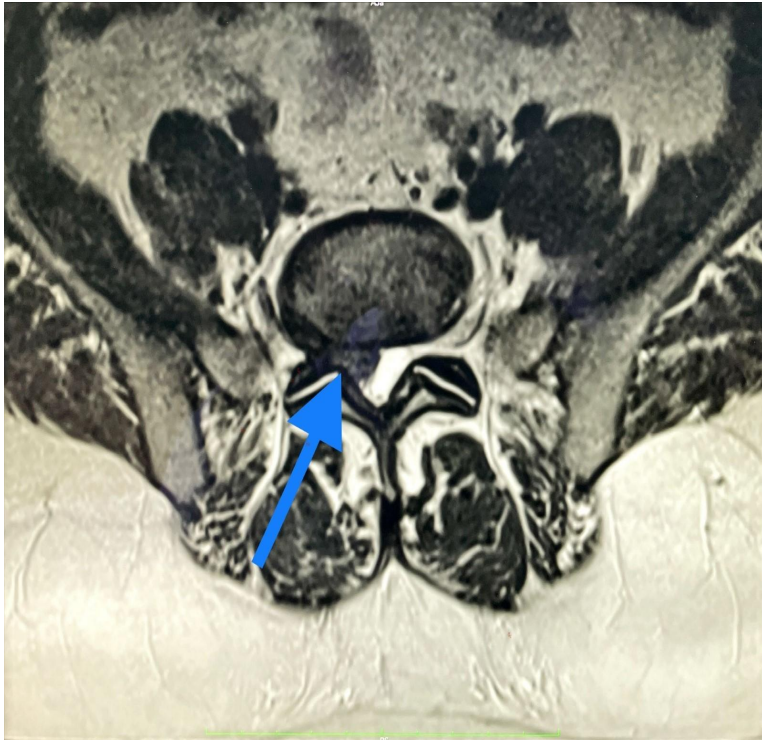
MRI - transverse section with a visible herniated L5/S1 intervertebral disc with compression on the thecal sac and the right S1 spinal root.
